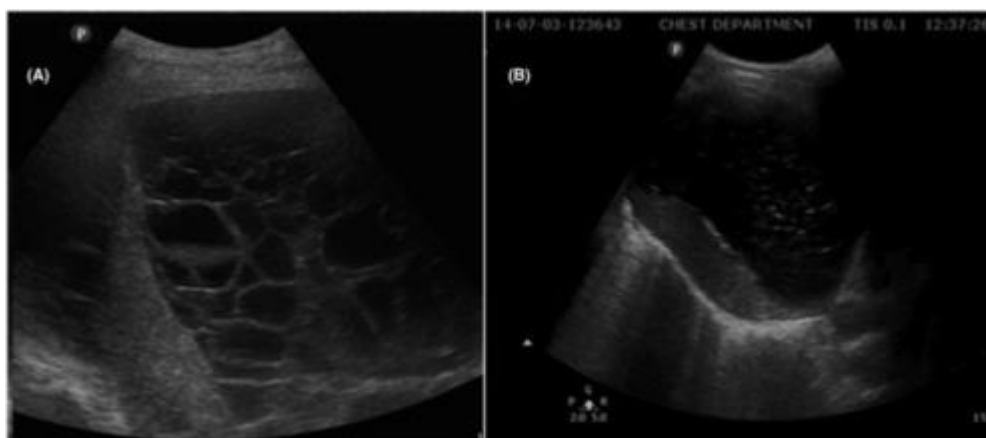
Ultrasound images of (A) heavily septated pleural effusion and (B) echogenic free pleural effusion (6)
